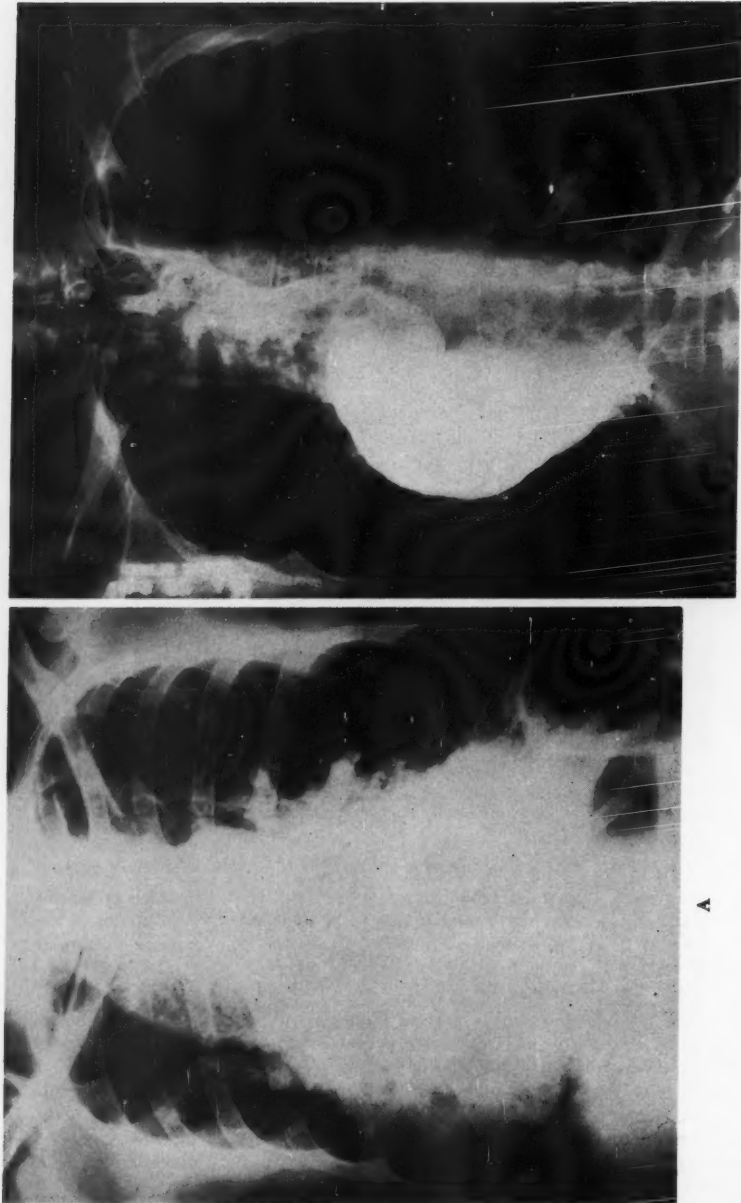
(Case 5) A. Roentgenogram of chest, showing enlargement of the esophagus extending beyond the right side of the heart. B. Esophagogram showing a greatly dilated and tortuous esophagus.
